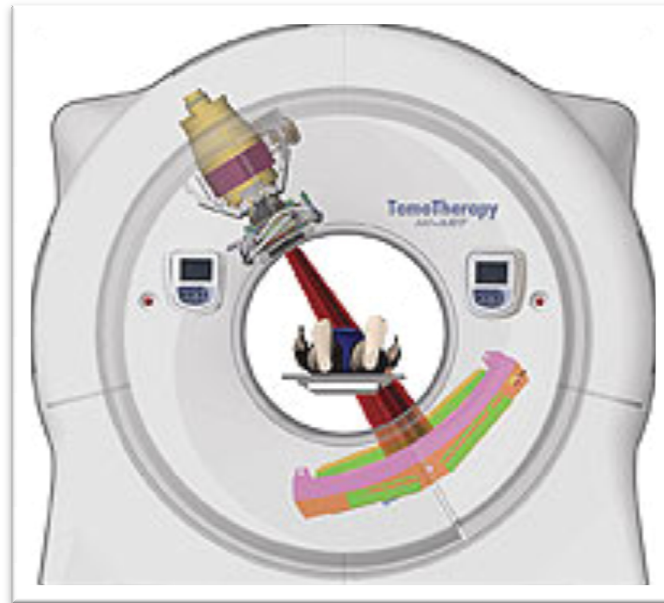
To perform Tomotherapy an x-band accelerator is mounted on a gantry of a helical CT scanner (10).
